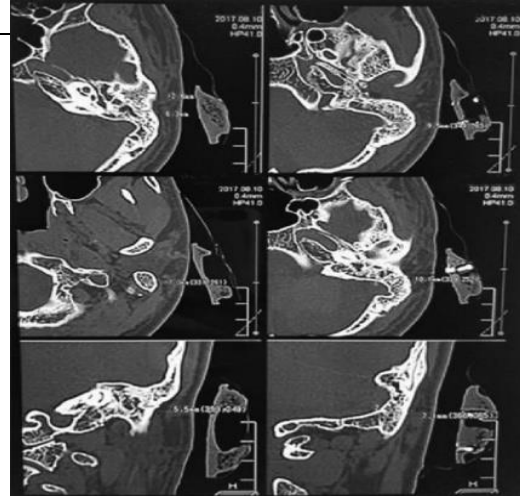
Radiographic view
